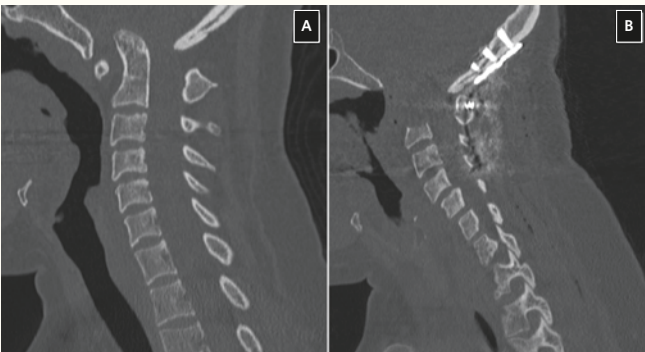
Non-contrast sagittal CT of the cervical spine. A) Preoperative scan indicating severe basilar invagination and canal compromise by the odontoid. B) Postoperative scan indicating complete resection of odontoid process and occipitocervical fusion.
